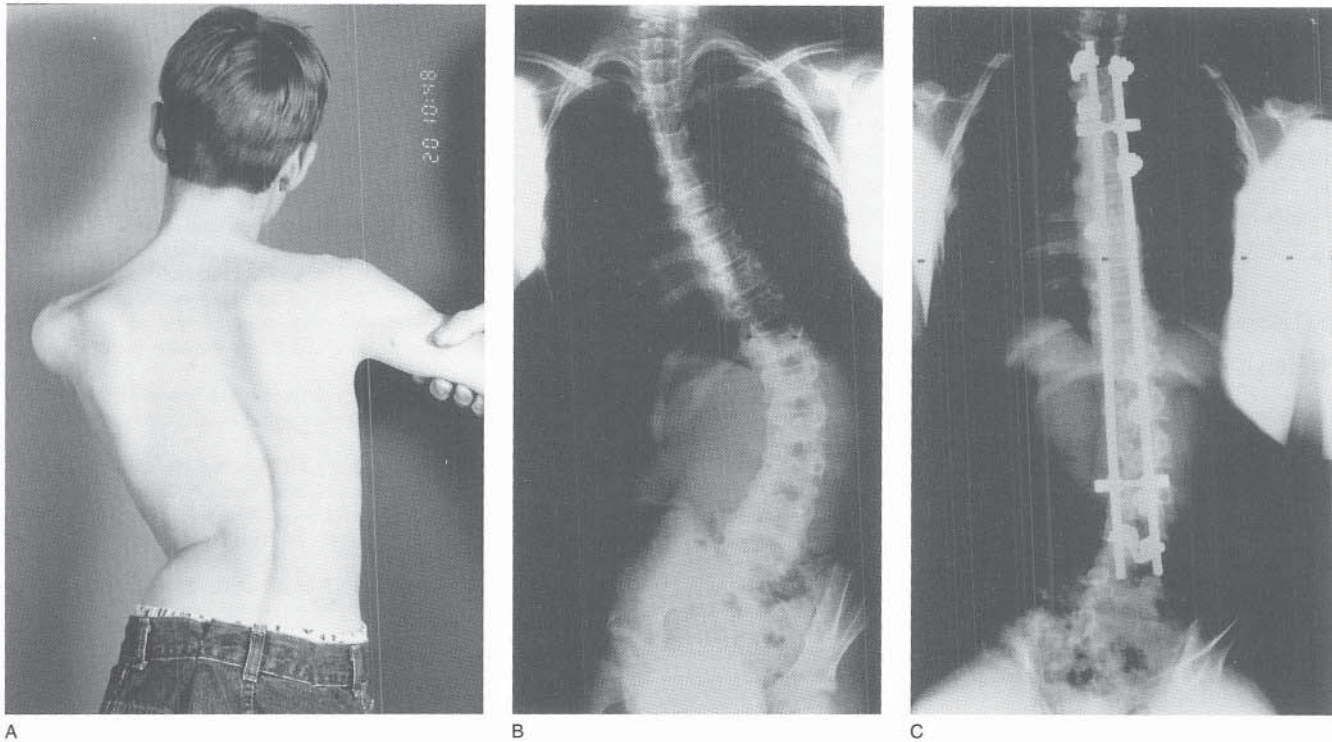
A, Clinical appearance of a 14-year-old boy with scoliosis secondary to Friedreich's ataxia. Because of poor balance he needed his father's assistance to stand for the photograph. B, Preoperative radiograph showing severe scoliosis and trunk decompensation. C, Radiograph obtained 6 months following posterior spinal instrumentation with TSRH instrumentation. The trunk balance has been improved.
